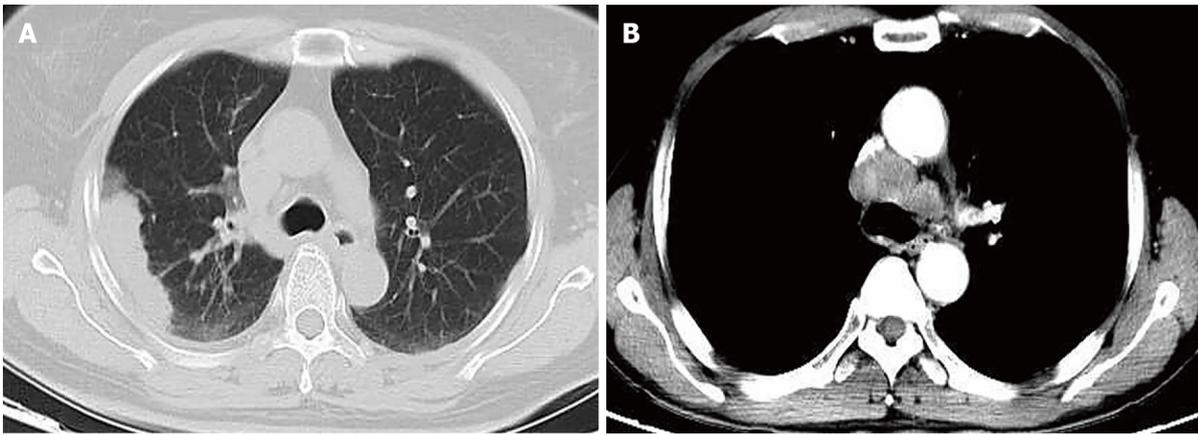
Chest computed tomography results of patients with primary pulmonary enteric adenocarcinoma. A: Case 4 with pulmonary enteric adenocarcinoma (PEAC) whose lesion was located in the right upper lobe; B: Case 1 with PEAC whose large lesion was located in the right lung, with mediastinal lymph node metastasis.
